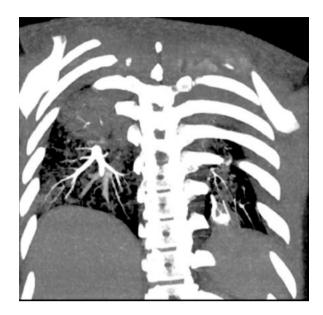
Sagittal CT image showing consolidation left lower and right upper lobe
